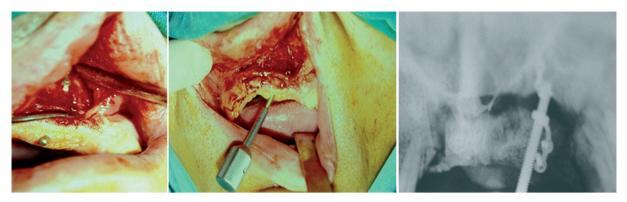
Distraction osteogenesis device lodged at the alveolar patient of a patient (left). The functionality of the device is tested by the operator with a specially designed screwdriver (center). After the end of the tension appliance period, the result is examined radiographically.
